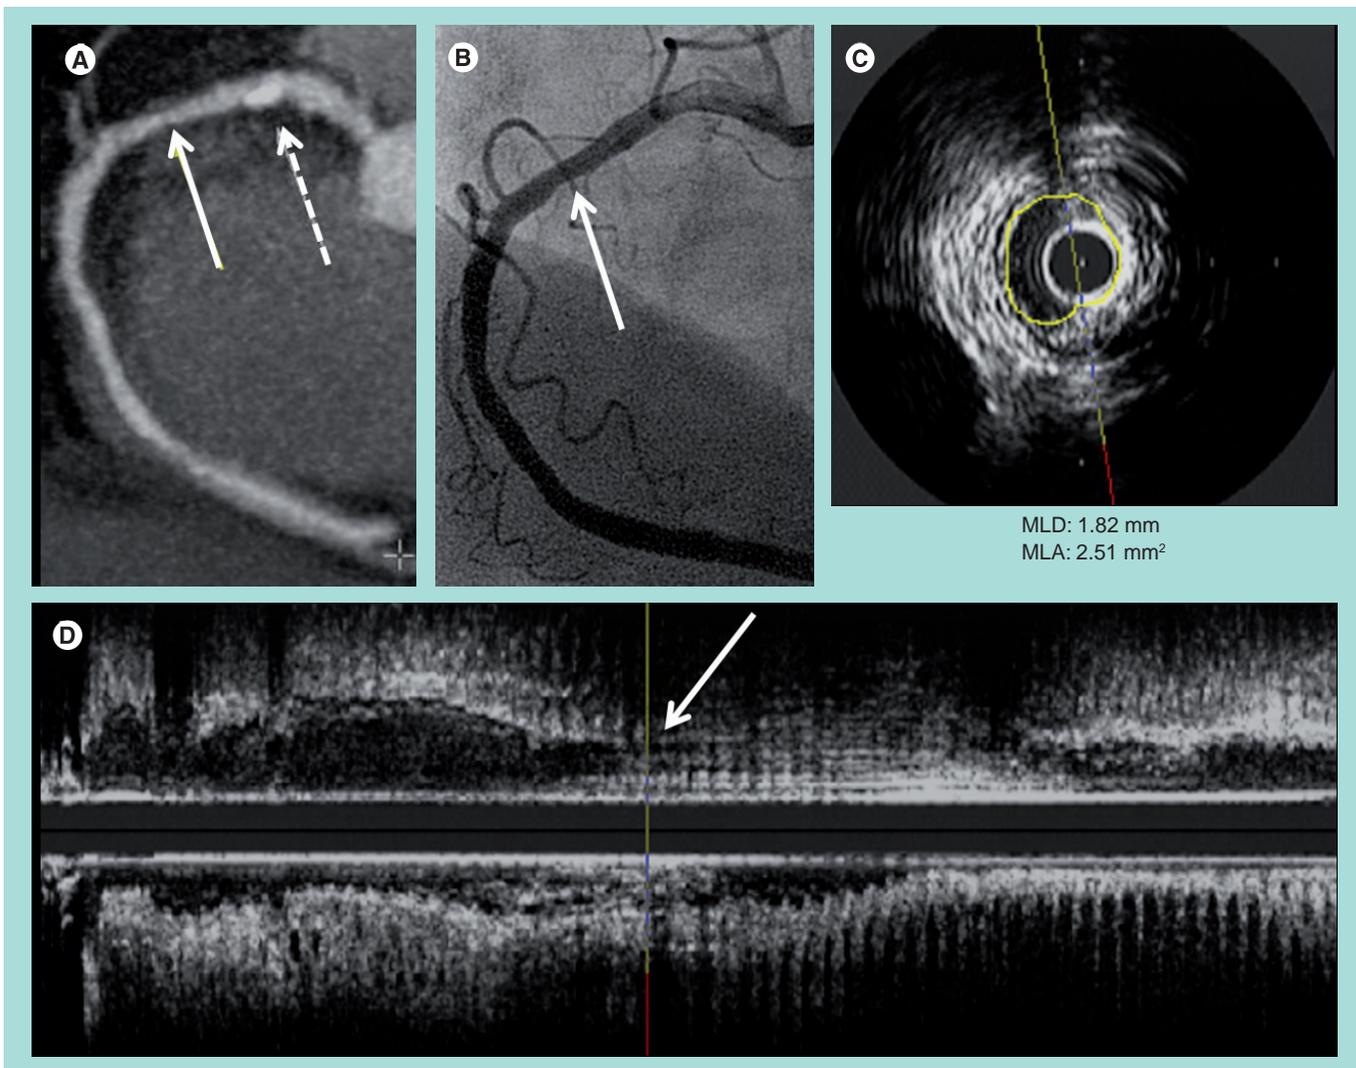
Angiographic underestimated lesion severity compared with intravascular ultrasound and computed tomography angiogram. (A) Multiplanar cardiac CT reconstruction showing the presence of a moderate stenosis caused by a noncalcified plaque (full arrow) and a more proximal severe calcified lesion (dashed arrow) involving the proximal right coronary artery. (B) Angiography of the same vessel showing the presence of a 30% stenotic lesion in the proximal RCA. (C) Cross-sectional intravascular ultrasound view of the pointed lesion (full arrows in [A, B & D]) showing the presence of a mixed plaque that determines a severe stenotic lesion. (D) Long intravascular ultrasound run view of the RCA. MLA: Minimal lumen area; MLD: Minimal lumen diameter.
